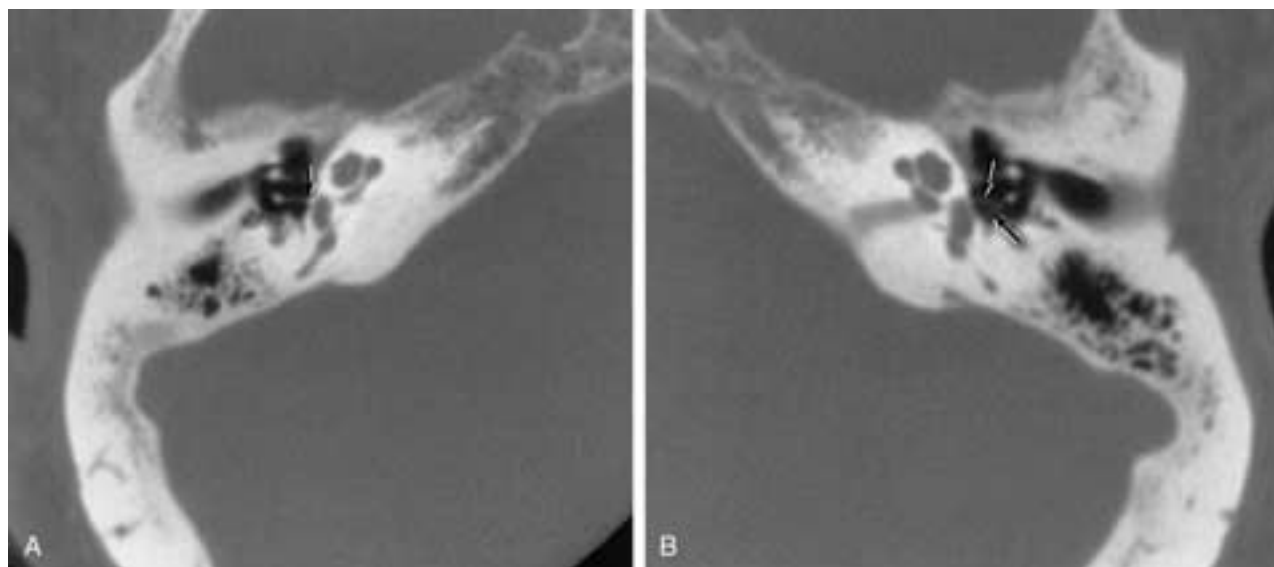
Normal wire stapes prosthesis. A, Axial CT image shows wire stapes prosthesis (arrow) in the oval window. B, Axial CT image of the normal left ear with intact stapes (arrows).
